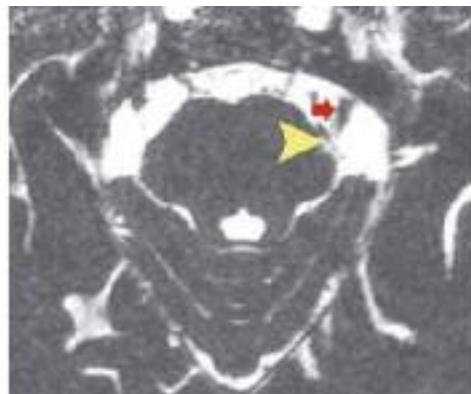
Axial MRI image displaying a neurovascular conflict; Trigeminal nerve (red arrow), blood vessel (yellow arrow).
